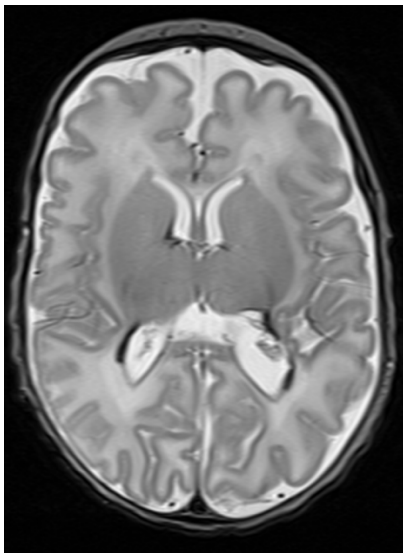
Axial T2 weighted MR image showing bilateral IVH
